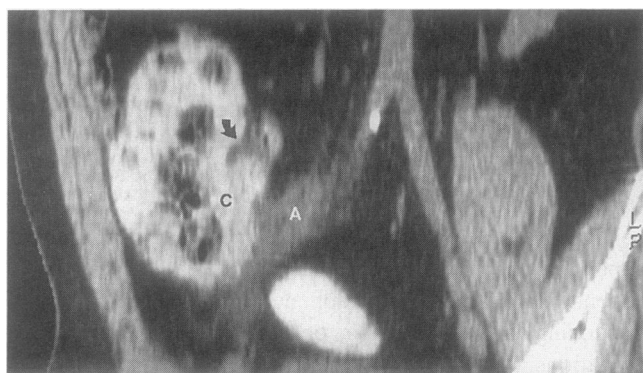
Coronally reformatted CT image of a 40-year-old man with a distended, inflamed appendix (A) arising off the cecum (C) caudal to the ileocecal valve (*arrow*).
